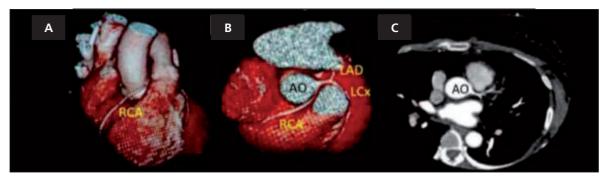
The 3D reconstruction CT showed (A) an anomalous origin of RCA from left coronary sinus (CS) with (B) subsequent coursing between the aorta and pulmonary trunk. (C) Multi-planar CT showed the anomalous origin of RCA from left CS with inter-aortic course.
